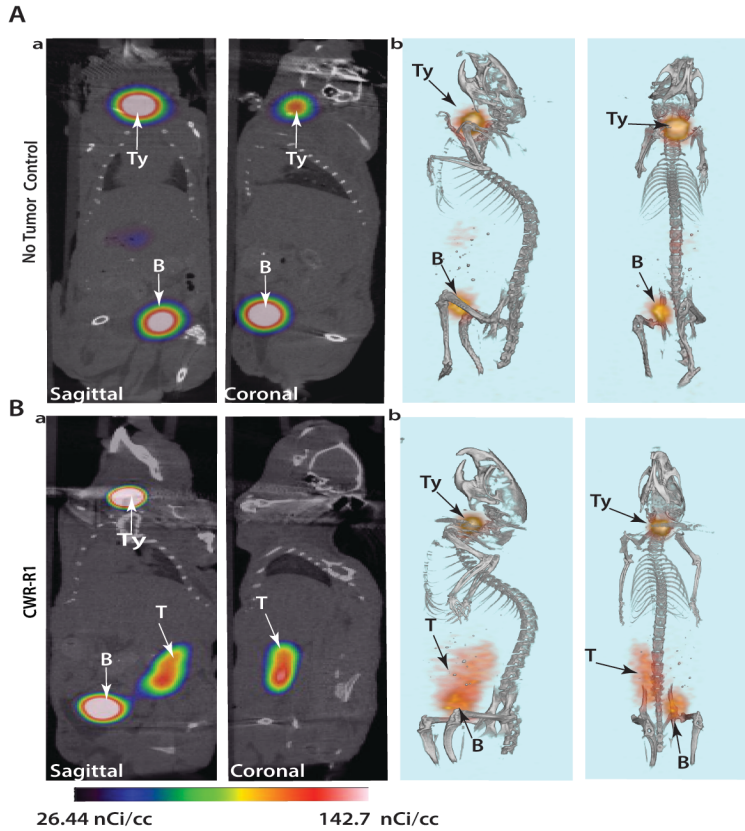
In vivo* PET/CT imaging with PEG10 promoter guided expression of HSV1-TK of subcutaneous CWR-R1 model.
